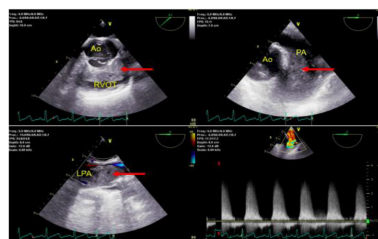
Intraoperative Transesophageal echo (TEE) demonstrating mass (red arrow) in the RV cavity and RVOT involving the pulmonary valve with pulmonary stenosis. There is extensive invasion into the RV, main PA and left PA with diminished blood flow. (Ao = Aorta; PA = Pulmonary artery; RVOT = Right ventricular outflow tract; LPA = Left pulmonary artery).
